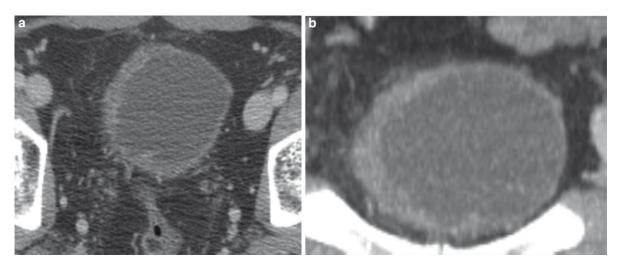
T2 bladder tumor. Axial (\mathbf{a}) and coronal CT (\mathbf{b}) of a 44-year-old male. There is diffuse bladder-wall thickening, primarily on the right side laterally, without evidence of extravesical extension. It is not possible to determine the depth of invasion within the bladder wall
